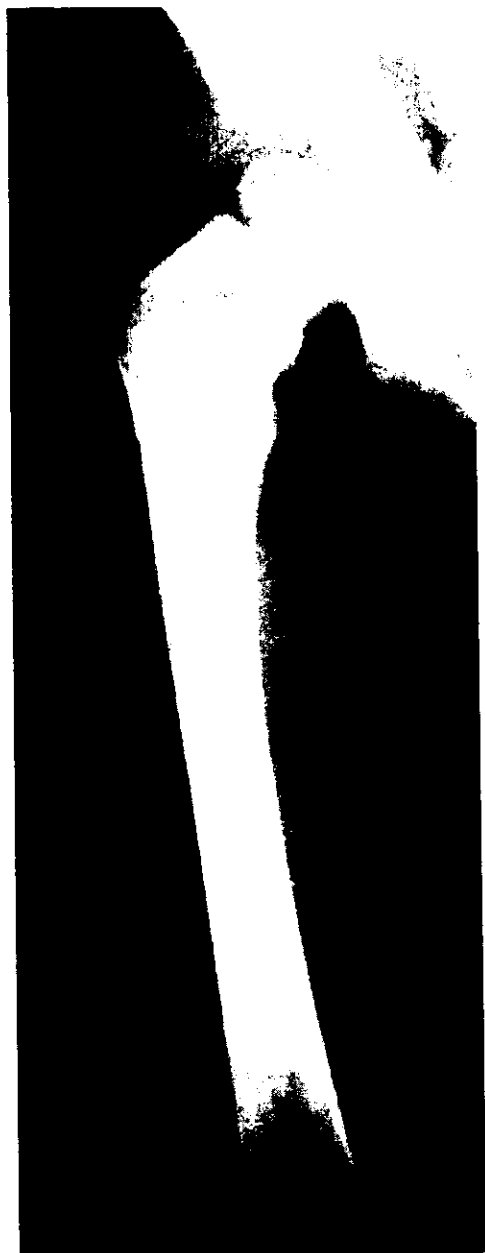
Radiograph of right femur showing an osteolytic bone lesion in the right proximal femur with periosteal reaction.
